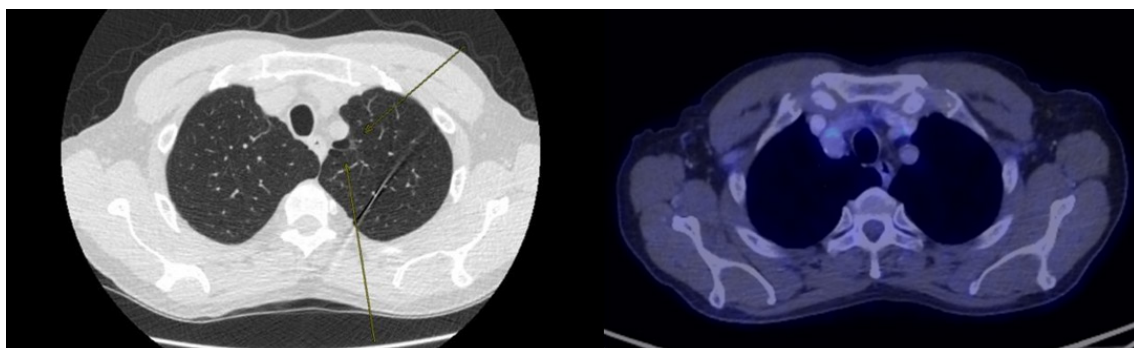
(A) Non-contrast chest CT (axial view) demonstrating multiple thin-walled emphysematous bullae in the apical segment of the left upper lobe. The largest bulla measures approximately 14.6 mm in diameter and shows no focal wall thickening or internal nodularity. (B) PET/CT scan showing no abnormal FDG uptake within these bullous changes.
